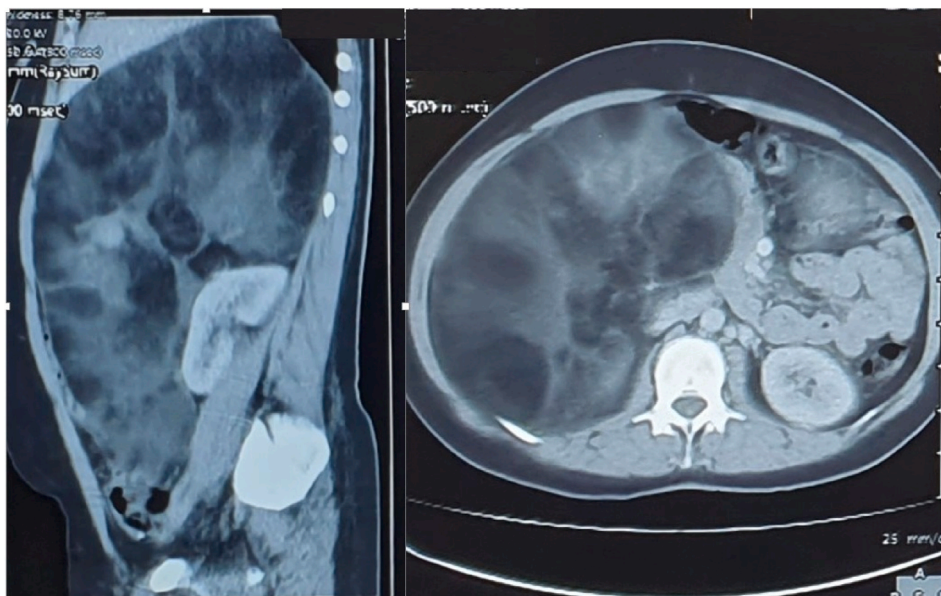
Preoperative abdominal CT scan demonstrating an encapsulated, hypodense, right retroperitoneal mass, containing fat, interspersed soft tissue attenuation components and few septa.
